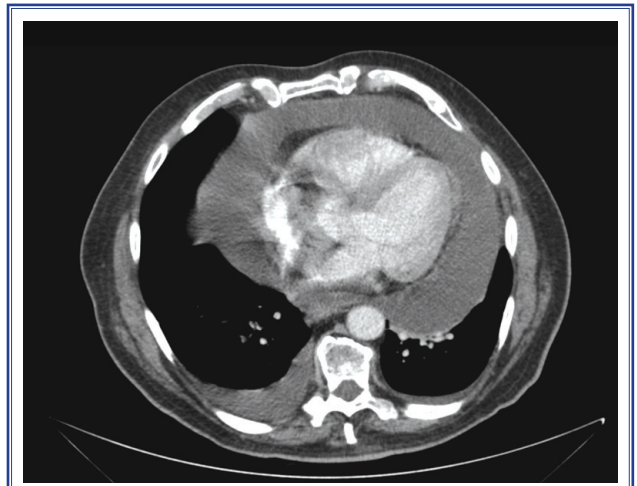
CT scan after 6 months.
